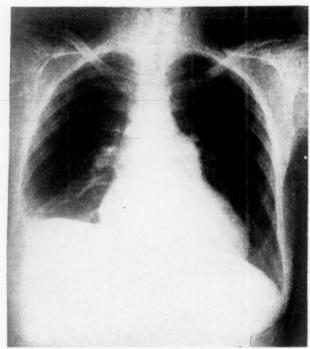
Roentgenogram obtained on December 21, 1956, showing cor pulmonale and pulmonary infarct, right costophrenic angle. Diminished vascular markings are present in both lung fields.
